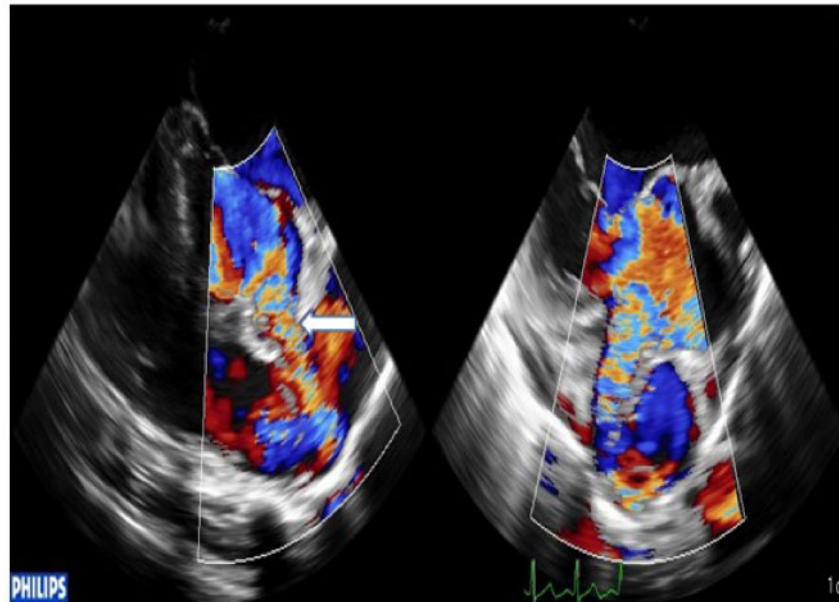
Long-axis two-dimensional colour Doppler views showing fistula (white arrow) between the aorta and main pulmonary artery with left to right shunt.
